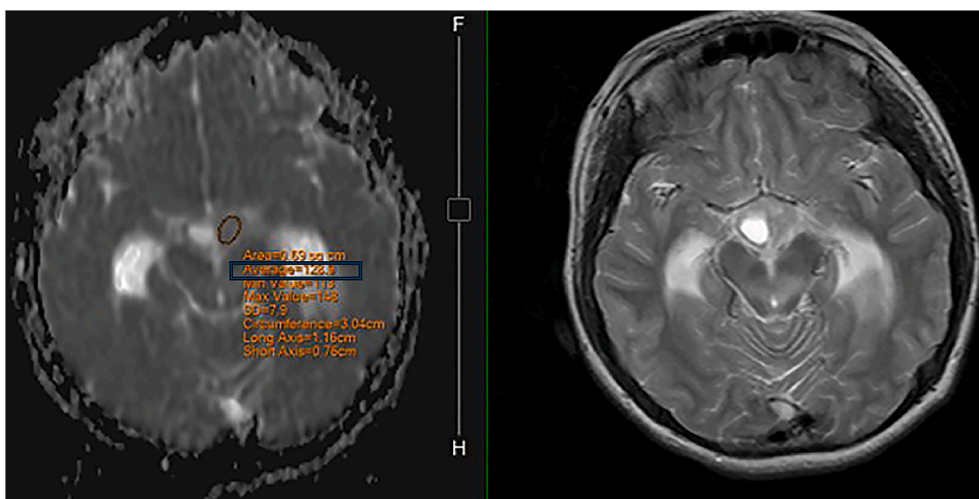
In this same patient, to measure the ADC value of the "solid part," the ROI was carefully positioned in the solid tumor area on the ADC map, intentionally excluding the sizable cystic region. The T2-weighted image served as a reference to enhance visibility of the tumor boundaries and cysts.
